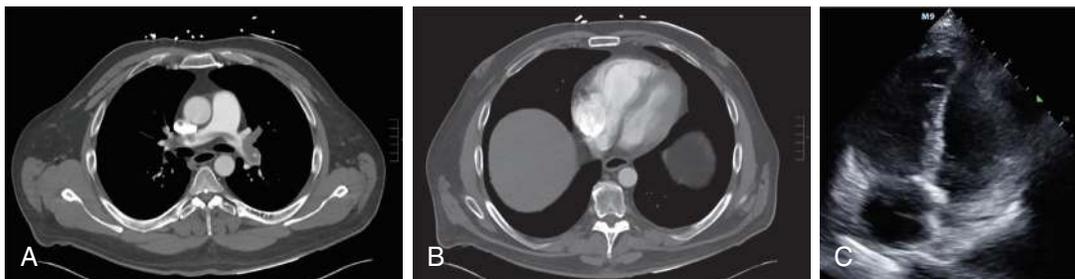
Suggested Management of the Patient with Acute PE. A, Acute pulmonary embolism. Cross-sectional computed tomography angiography (CTA) using a pulmonary angiography protocol showing a large bilateral acute pulmonary embolism overlying the main pulmonary bifurcation (“saddle PE”). B, Acute right heart strain. Cross-sectional CTA using pulmonary angiography protocol reveals an enlarged right ventricle in the setting of acute pulmonary embolism, suggestive of acute right heart strain. C, Acute right heart strain on ultrasound. Ultrasonographic apical four-chamber view of the heart showing acute right heart strain. The right ventricle (left side of the image) is larger than the left ventricle, a pathologic finding. (Images A and B courtesy of Dr. Jeffrey Shyu, Brigham and Women’s Hospital, Boston, MA. Image C courtesy of Dr. Heidi Kimberly, Brigham and Women’s Hospital, Boston, MA.)
